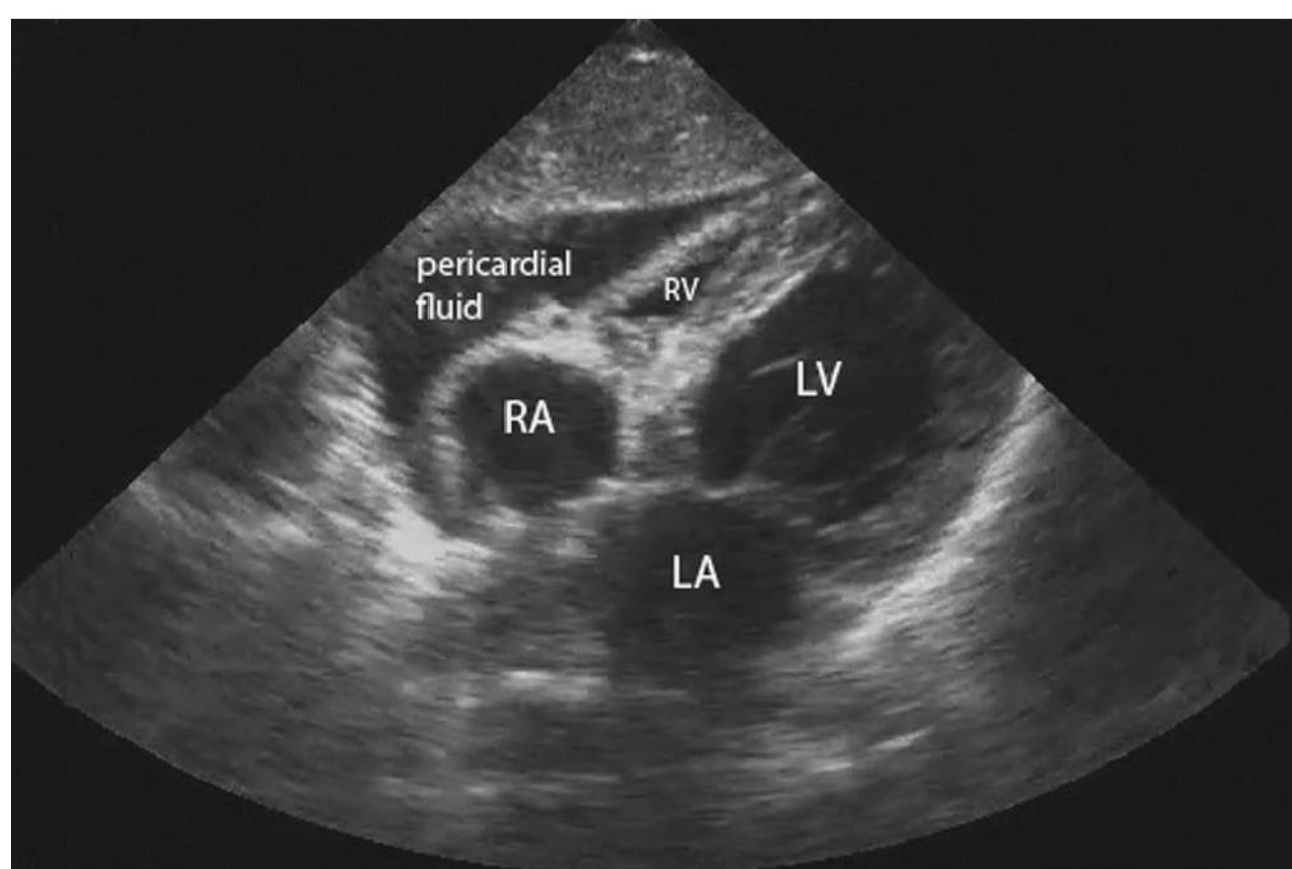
■ Ultrasound of Cardiac Tamponade. This subxiphoid view of the heart reveals a large pericardial fluid collection and compression of the right ventricle (RV) suggesting tamponade physiology. (Photo contributor: Department of Emergency Medicine, Ultrasound Section, Vanderbilt University.)
